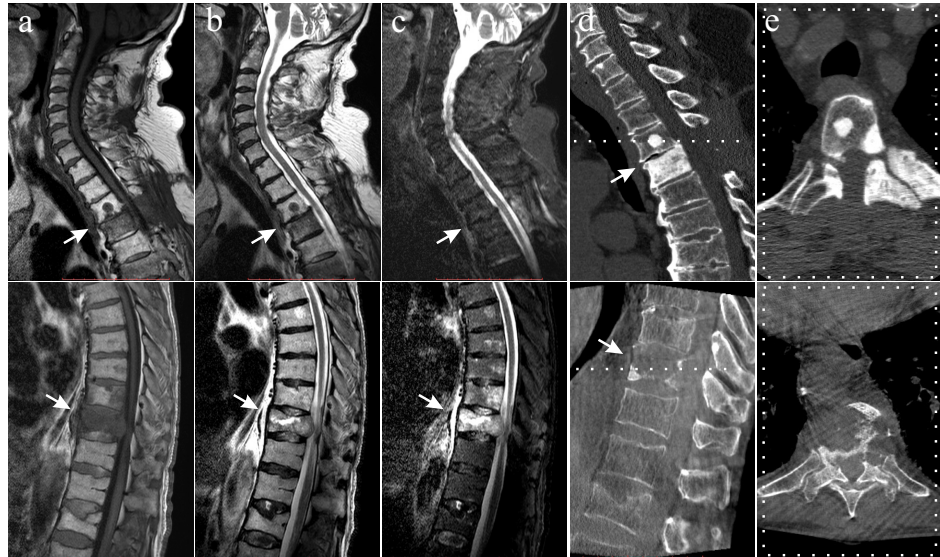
Appearance differences of sclerotic (upper row) and lytic (bottom row) spinal metastases (arrows) in MRI and interventional CT imaging. Displayed are two exemplary patient cases with sagittal T₁-weighted (a), T₂-weighted (b), and STIR (c) MRI sequences as well as their corresponding interventional FP-CT scans in a mid-sagittal (d) and an axial cross-section (e). Especially in X-ray-based imaging, the different physiological processes regarding the bone alteration of both lesion types can be vividly visualised.
